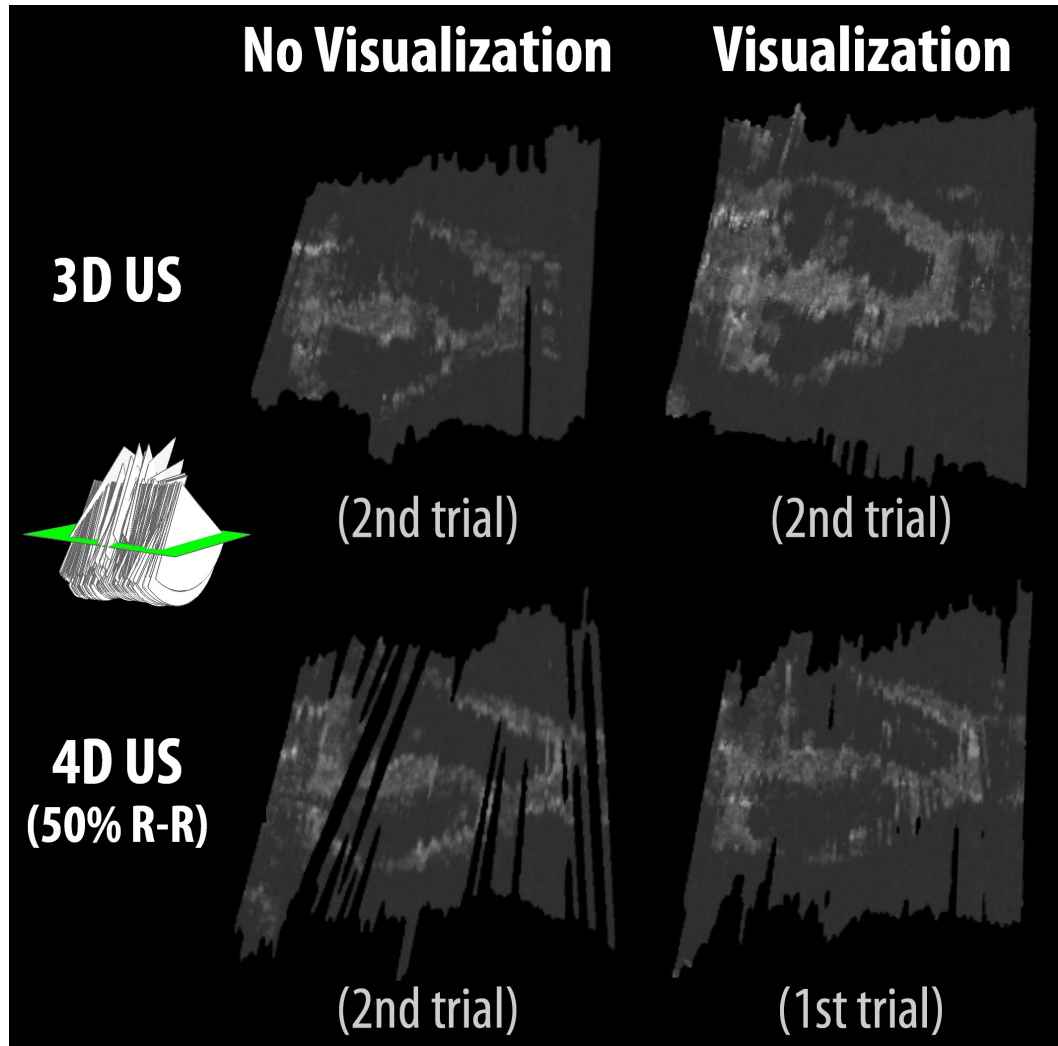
Example output volumes acquired with and without real-time visualization during the human factors experiment, for both 3D and 4D ultrasound reconstruction. The output volumes are displayed after hole-filling in the equivalent of a four-chamber view. All images represent the clinician's second trial under each imaging paradigm with the exception of the 4D ultrasound reconstruction with real-time visualization, which shows the first attempt. (US depth setting = 14 cm,  $s_{in} = 0.40$  mm,  $s_{out} = 0.81$  mm; for 4D US reconstruction  $HR_{exp} = 17$  bpm,  $\%dev_{HR} = 1.5\%$ ,  $N = 2$ ,  $P = \{0, 1\}$ , images shown represent the 50% R-R interval).
